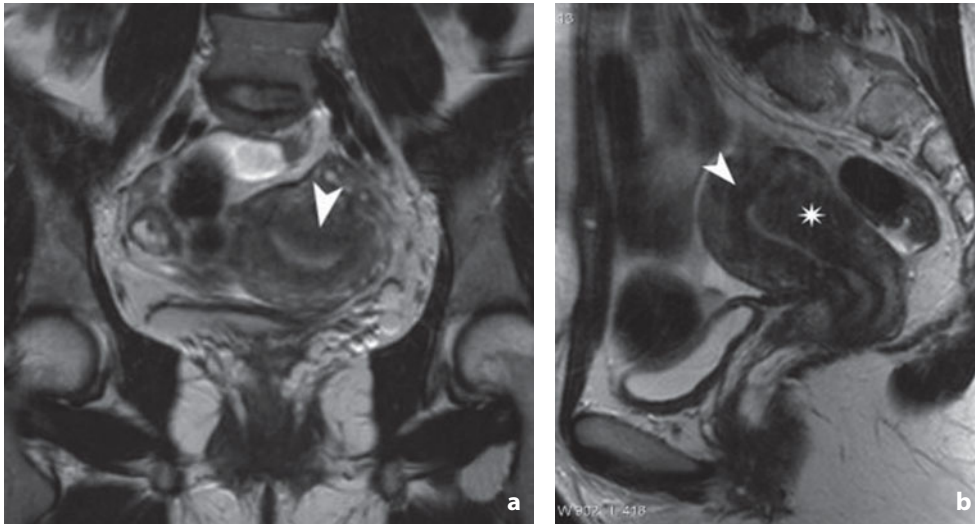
Magnetic resonance. Adenomyosis, focal form. Coronal (a) and sagittal (b) T2-weighted images. Diffuse thickening of the junctional line (*arrowhead*) with focal alteration of the signal of the myometrium (*asterisk*)
